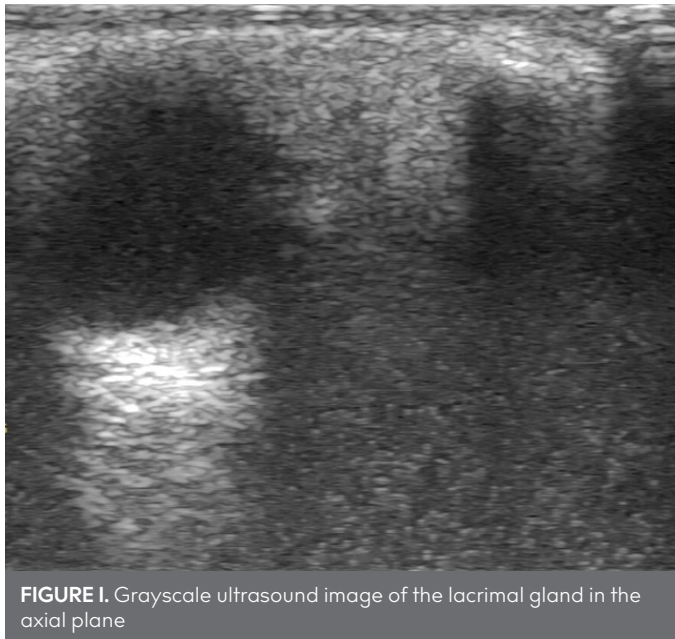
Grayscale ultrasound image of the lacrimal gland in the axial plane
